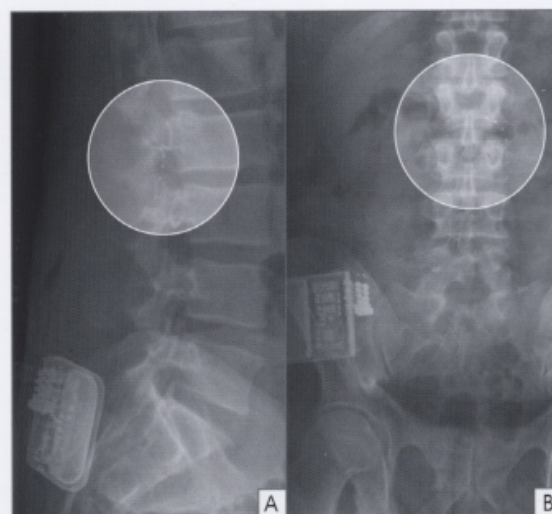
Patient 1 X-rays of implanted neurostimulation system for SCS of the DRG. (a) Lateral and (b) anterior views.
